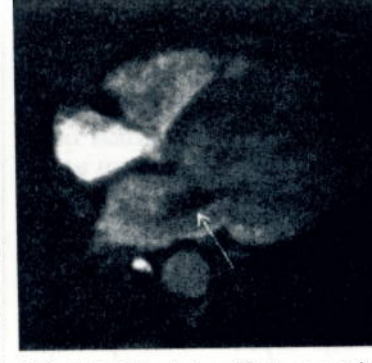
Mitral insufficiency with valvular vegetation. Transverse cine MR image with TE of 7 msec reveals a regurgitant jet due to mitral insufficiency within the left atrium (arrows).
